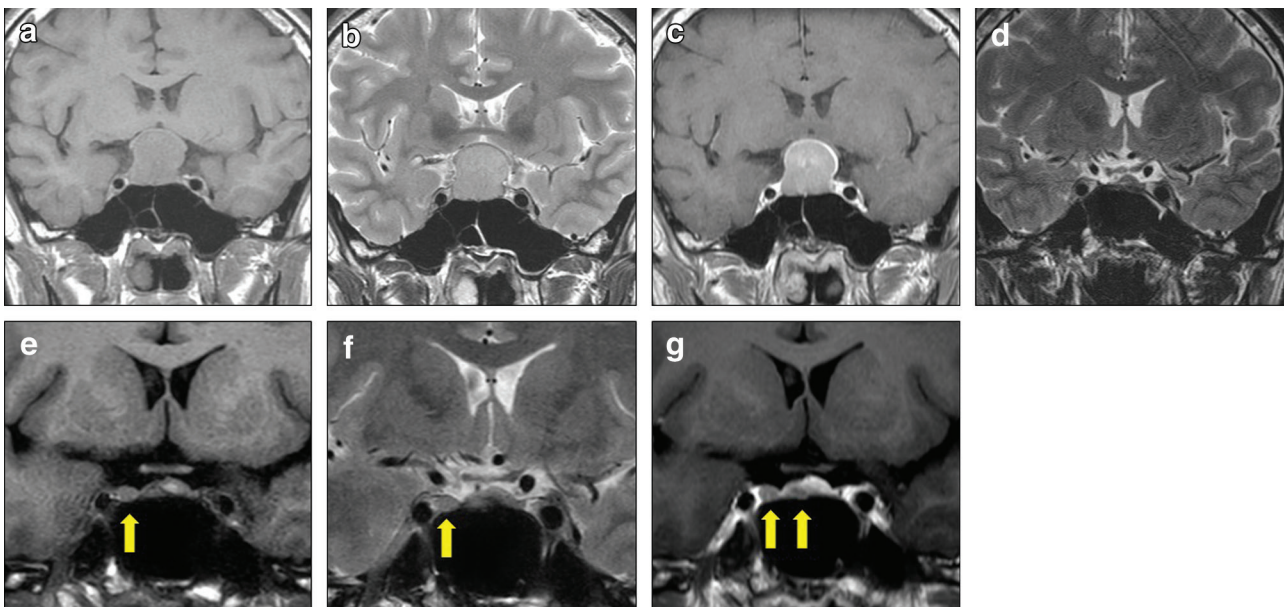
(a)–(d) are MRIs of the sellar region at the age of 18. Coronal T1-weighted image (a), coronal T2-weighted image (b), and coronal contrast-enhanced T1-weighted image (c) show a homogenous lesion in the sellar to suprasellar region. Coronal T2-weighted image after initial TSS (d) confirms GTR of the tumor. (e)–(g) are MRIs of the sellar region at the age of 25. Coronal T1-weighted image (e), coronal T2-weighted image (f), and coronal contrast-enhanced T1-weighted image (g) show a small dumbbell-shaped homogenous lesion on the right side of the sellar region (arrow). GTR: gross total resection; TSS: transsphenoidal surgery.
